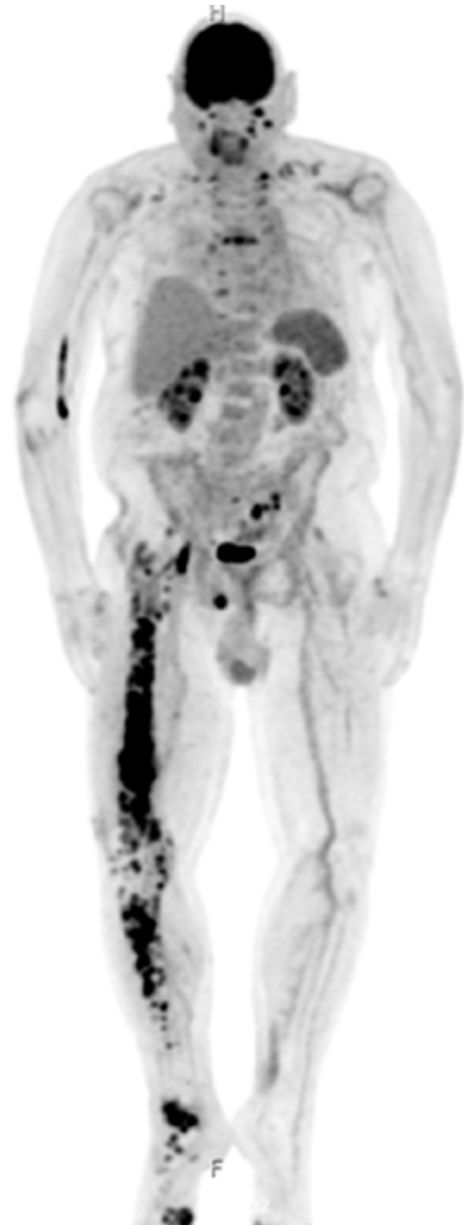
PET CT showing multiple lesions within right femur, tibia and foot.
